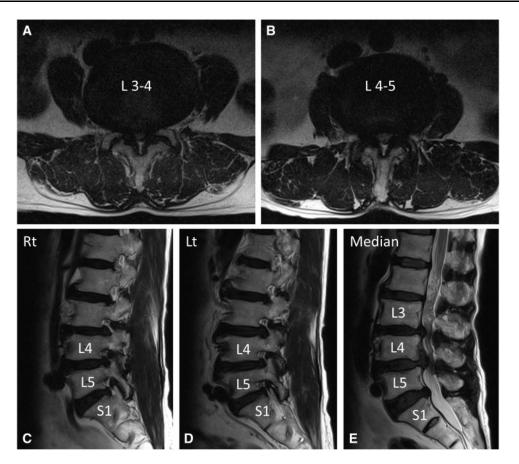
Preoperative lumbar magnetic resonance images (MRIs) of the patient (55-year-old female), who complained of low back pain and sciatica (both L5 dermatomes). A, B) The T2-weighted axial MRIs at L3–4 and L4–5 showed moderate to severe central spinal stenosis. C, D, E) The T2-weighted sagittal MRIs showed bilateral neural foraminal stenosis at L5–S1 (C and D) and central spinal stenosis at L3–4 and L4–5 (E).
